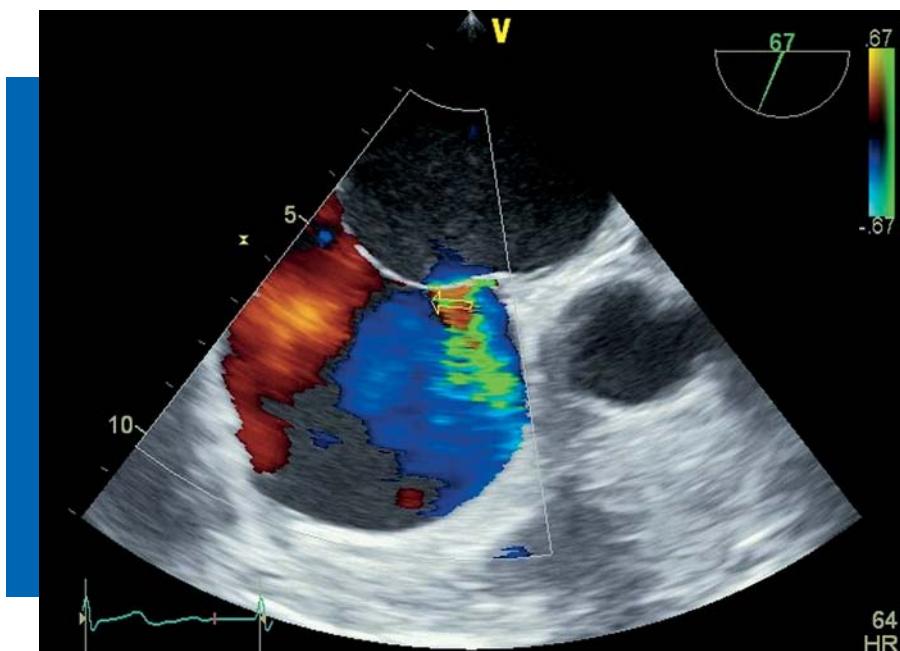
Two-dimensional transesophageal echocardiography presenting left-right atrial shunt using color Doppler.
